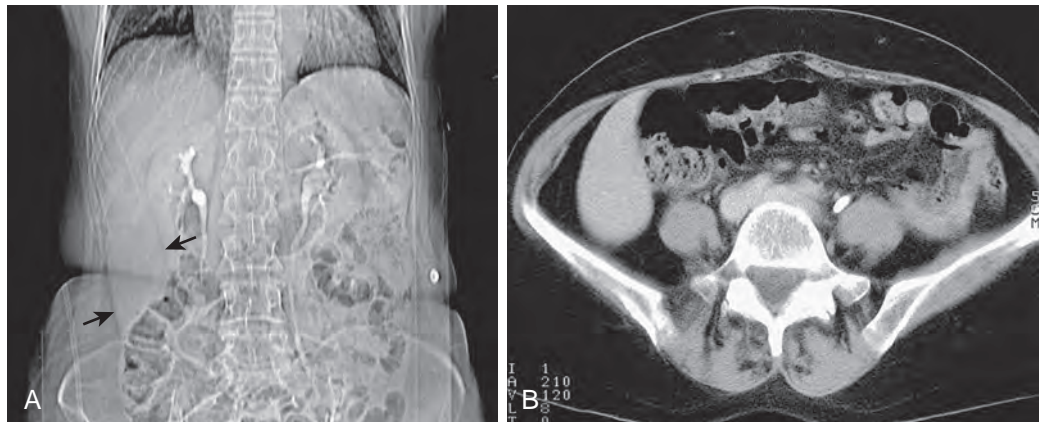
Riedel's lobe. Coronal reformatted CT scan displays an elongated inferior extension of the right lobe of the liver (arrows) characteristic of Riedel's lobe.
